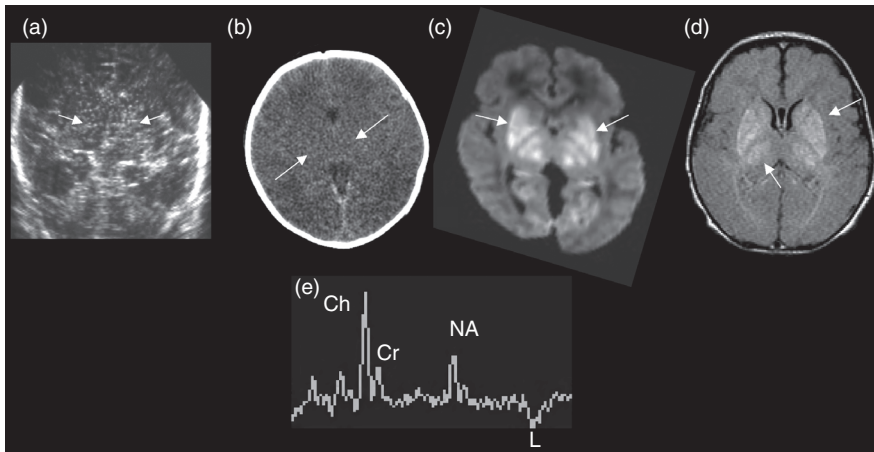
Profound HIE: acute phase with (a) bilateral basal ganglia and thalamic hyperechogenicity (arrows) on US; (b) hypodensities (arrows) on CT; high intensities (arrows) on (c) axial DWI and (d) T1/FLAIR MRI; and (e) inverted lactate doublet (L) on MRS.
